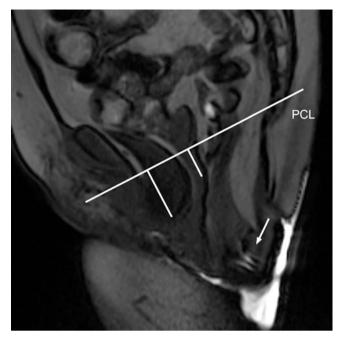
63-year old female patient with external rectal prolapse. MR image obtained during defecation shows an external rectal prolapse (arrow) and an additional moderate anterior and small middle compartment descent. *PCL* pubococcygeal line
